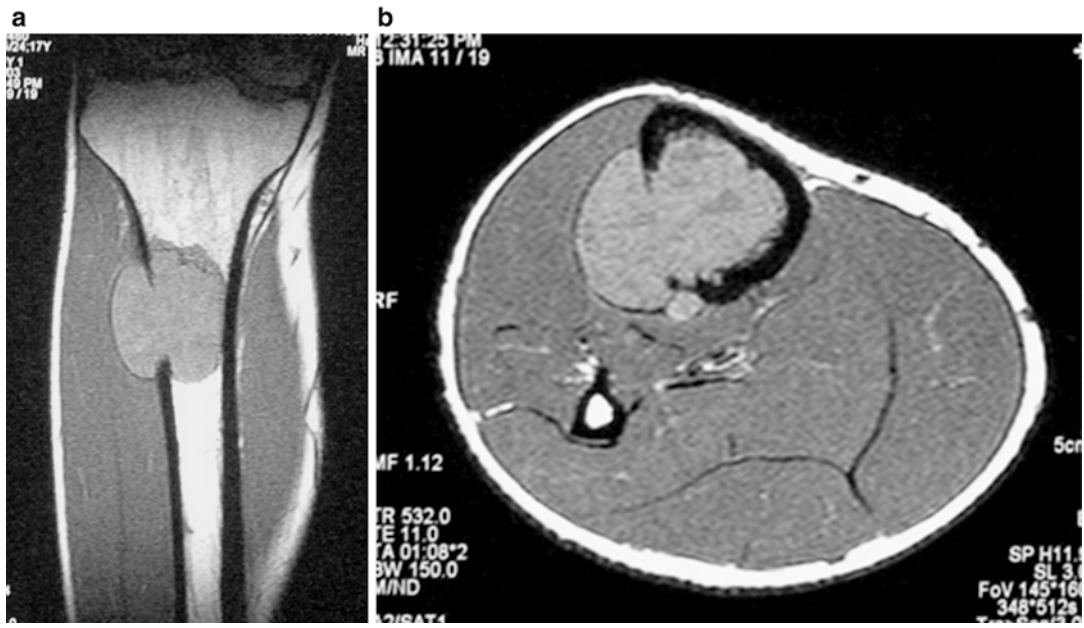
Pre-chemotherapy MRI
